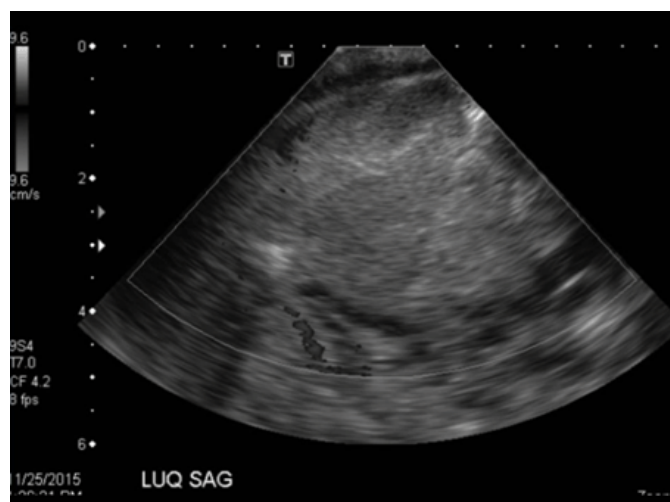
Ultrasound of the left lower quadrant mass with Doppler demonstrates no intralesional flow.
